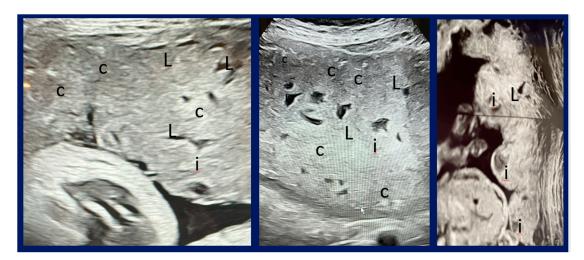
Depicted are three separate pregnant women's ultrasound images in the third trimester documenting the classic features that have been noted after COVID-19 vaccines administered during pregnancy. Many of these findings are consistent with the multiple pregnancy adverse events related to COVID-19 vaccines in pregnancy in this report including placental calcifications, placental insufficiency, placental infarction, placental thrombosis, placental accreta, placental disorders, reduced amniotic fluid volume, and fetal growth restriction. The images represent calcifications (c), lacunae (L), and infarcts (i).
